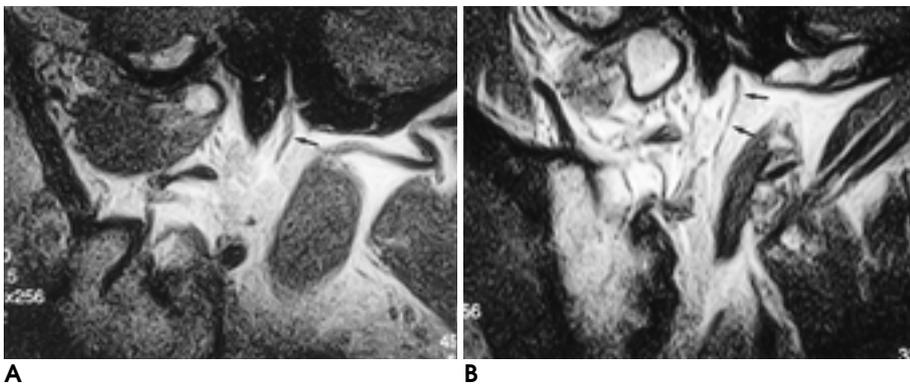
64-year-old man with chronic Bell's palsy. MR images were obtained 2 years after onset of symptoms.
